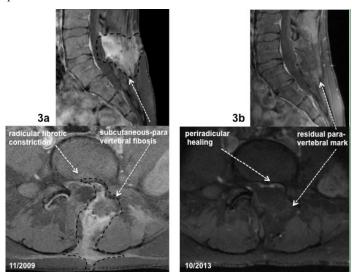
(a,b): Patient 2: repeated L5-S1 surgery- (a) postoperative sagittal and axial MRI with extensive epidural fibrosis (line); (b) half thickness fibrosis reduction after 5.5y PENTOCLO treatment.
